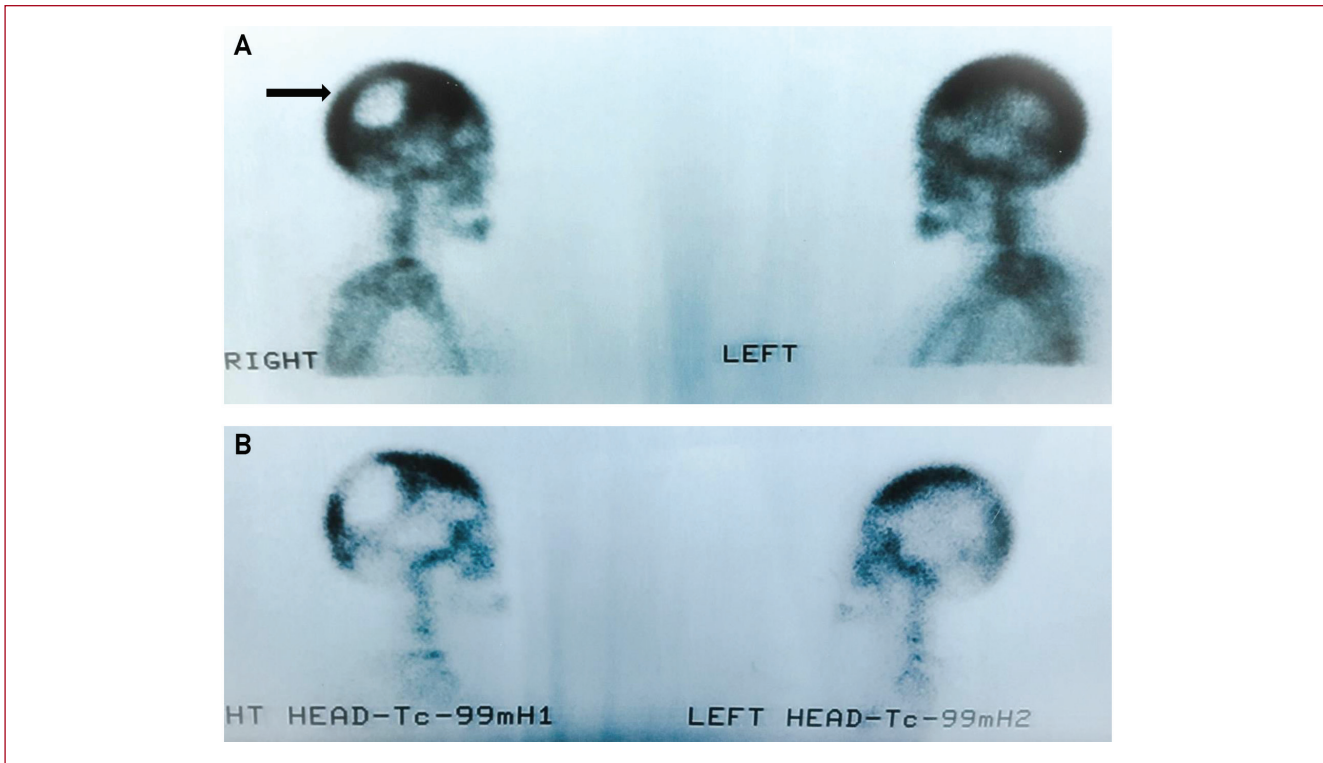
A 76-year-old female patient presented with severe headache at the neurosurgery department and underwent a surgical excision of a skull lesion misdiagnosed as a eosinophilic granuloma (arrow). Biopsy findings, SAP levels elevation and a later bone scan (A) established the diagnosis of PDB. Treatment with a single dose of i.v. 5 mg of zoledronic acid resulted in relief of headache and in significant biochemical and scintigraphic response 4 months later (B). (From archive of Rheumatology Department, 417 Army Share Found Hospital (NIMTS), Athens, Greece).
